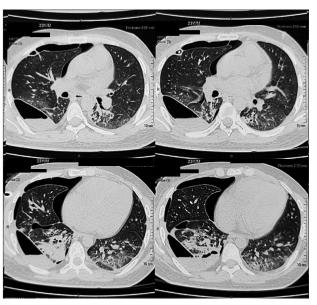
Serial contrast-enhanced computed tomography thorax lung window: Bilateral lower lobe healed parenchymal lesions with residual disease, with right-sided hydropneumothorax with an intercostal drainage tube in situ
